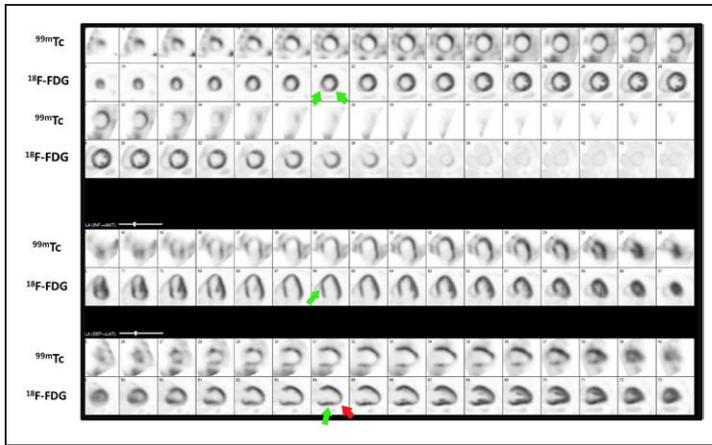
Dual-isotope single-photon emission computed tomography viability study.
